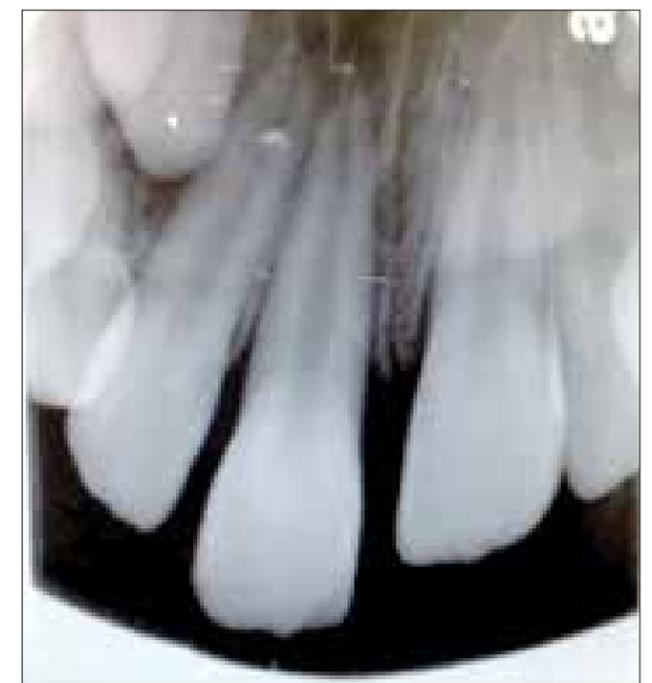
Periapical radiograph of tooth #8, eighteen days after trauma.
